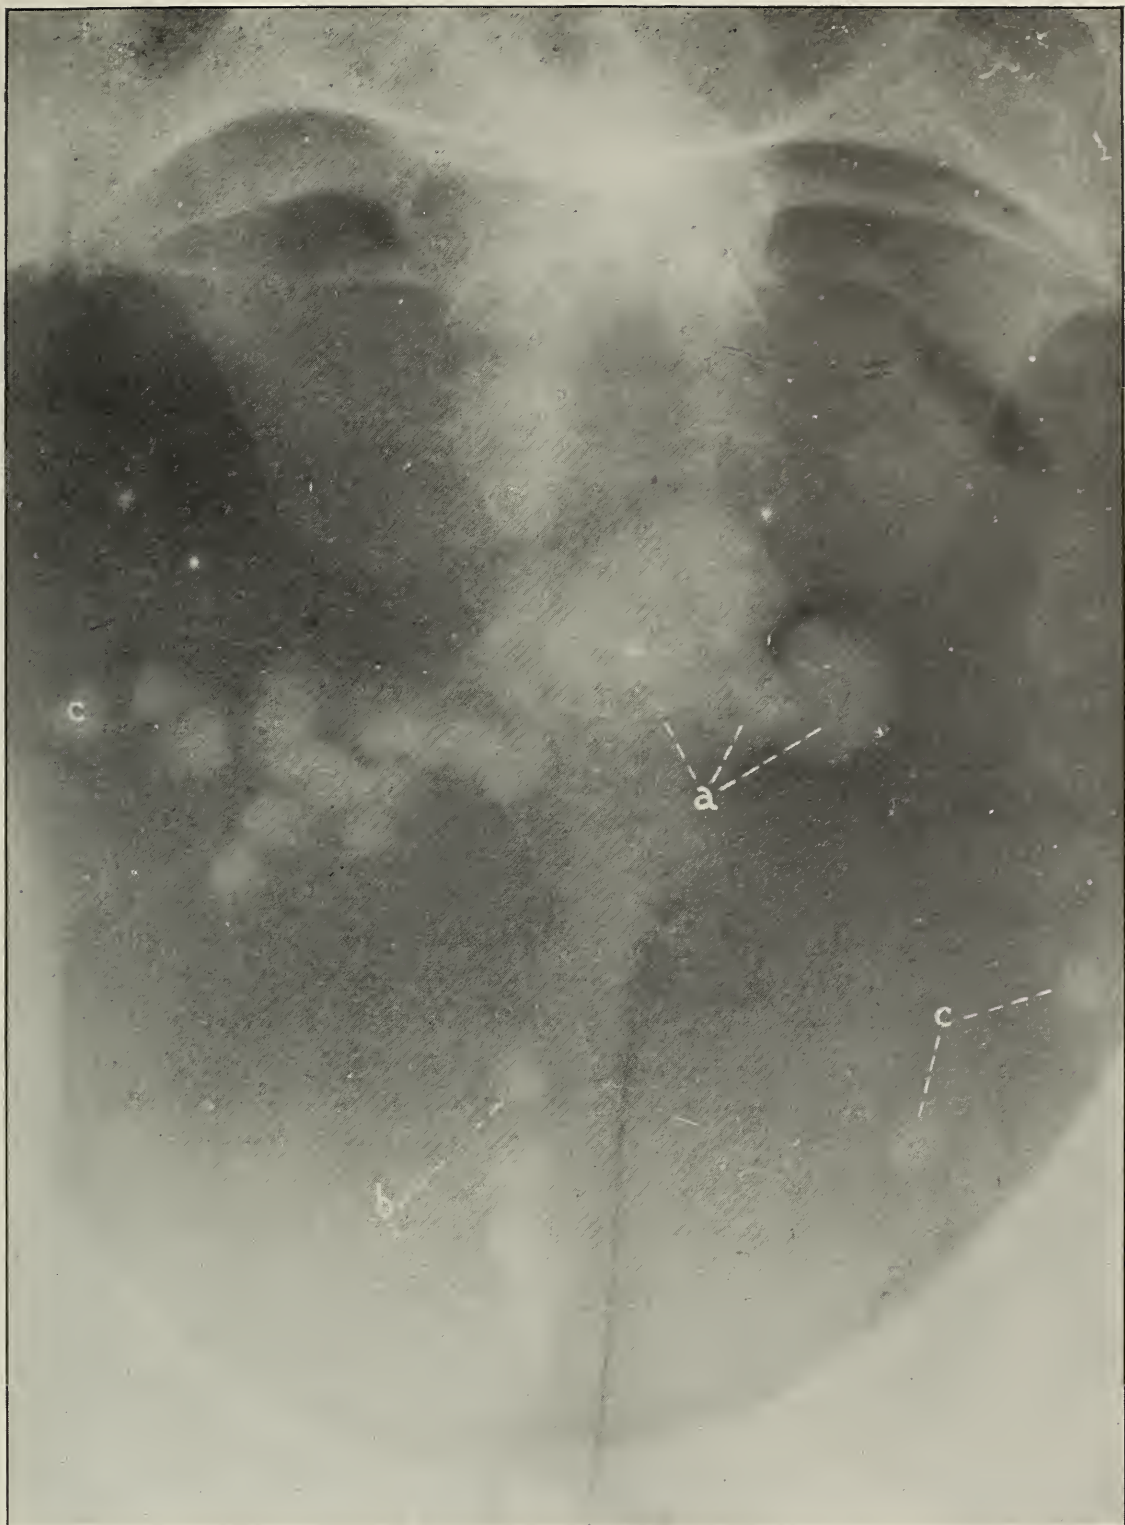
X-ray No. 9658. Region: bony pelvis. Original plate shows multiple shadows of various sizes. These must be identified. Diagnosis: (A) several stones in bladder, (B) multiple calcareous deposits in the prostate, and (C) vein stones. Confirmed at operation.
